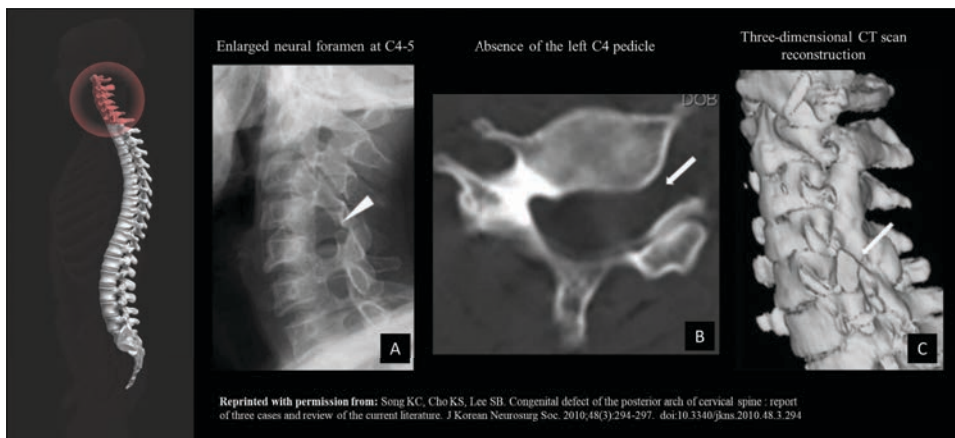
Posterior arch abnormality- Case of a 50-year-old woman. Left anterior oblique view displays an enlarged neural foramen at C4-5 (A). Cervical spine CT reveals the absence of the left C4 pedicle (B). Three-dimensional CT scan shows the absence of C4 left pedicle at C4-5 (C). Reprinted and modified with permission from ¹⁵⁷.
